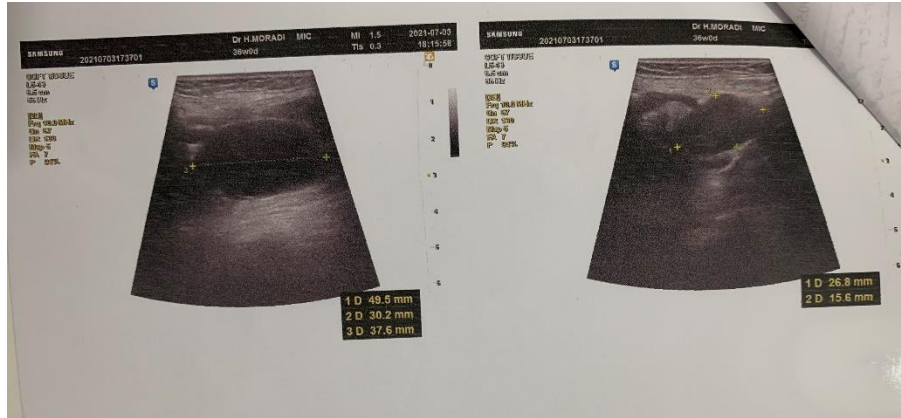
Ultrasound image of the left parotid gland showing cystic focus with a thick wall of 49×30×37 mm in the inferior parotid region. Several hypoechoic lymph nodes were seen with a maximum size of 27×15 mm. Findings were suggestive for solid mass, abscess, or infectious lesions
